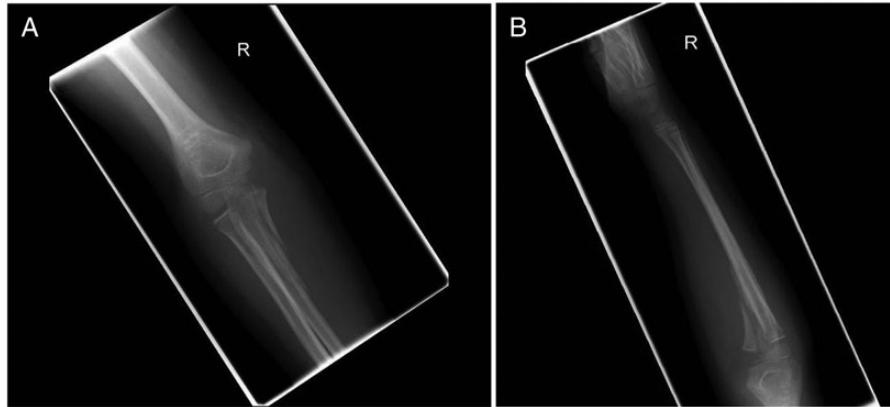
(A) Anterior–posterior radiograph of the elbow and (B) lateral radiograph of the elbow. Admission right elbow radiographs.
